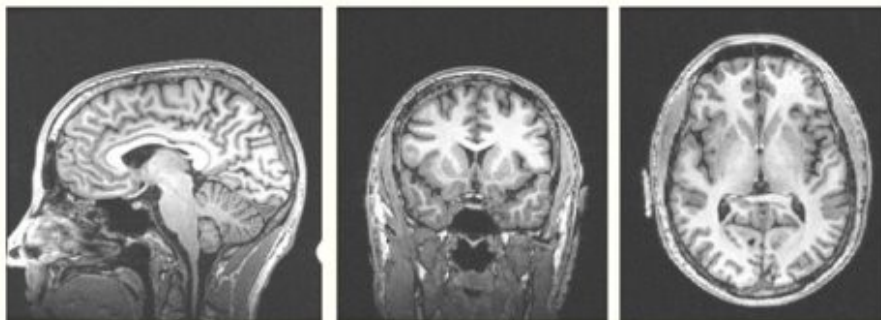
T1 weighted MRI image: Sagittal, Coronal, Axial View (Left to Right); Good contrast between grey matter (dark grey) and white matter (lighter grey) tissues. CSF is void of signal (black). Fat, such as lipids in myelinated white matter, appears bright [57]
